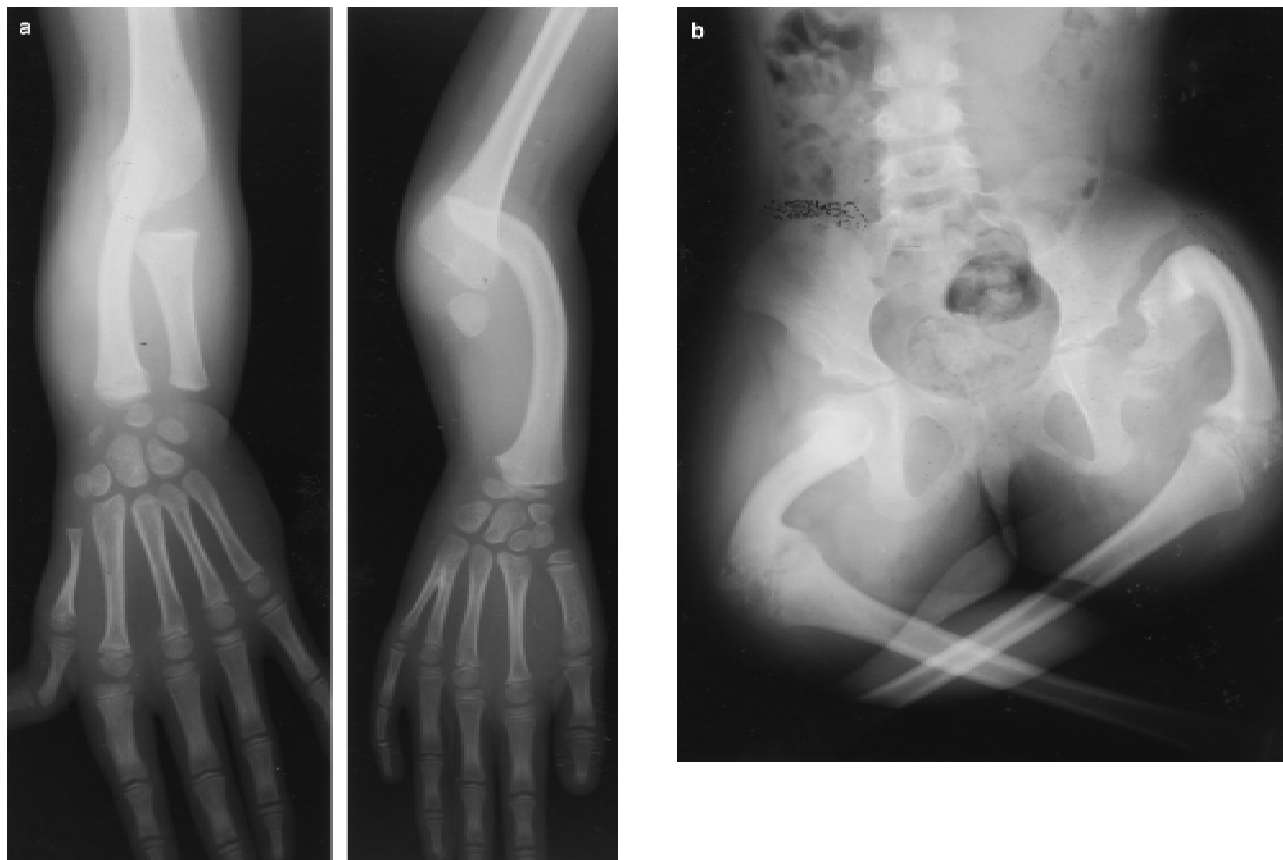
a: Roentgenographs of V-3 showing short/absent ulnae, bowed radii, hypoplastic 4th and 5th metacarpals and correspondingly small phalanges. b: Lower limbs of V-3 showing bilaterally hypoplastic angulated femora and absent fibulae.
